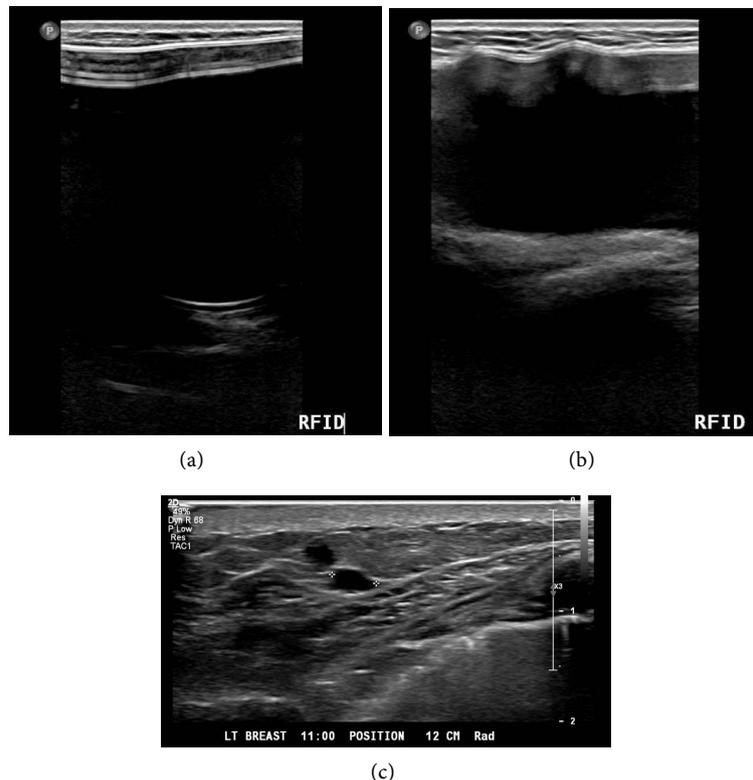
(a)-(c): Ultrasound image of the left breast at the site of the RFID micro-transponder (a) and (b). The posterior wall is visualized without artifactual distortion. There were two benign appearing cysts in the left breast of which the largest measures 4 mm in longest diameter at the 11 o'clock position 12 cm from the nipple. There are no suspicious sonographic findings. BIRADS 2—recommend annual breast cancer surveillance.
